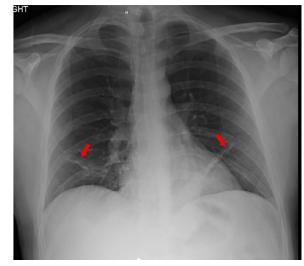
Radiography of the chest
